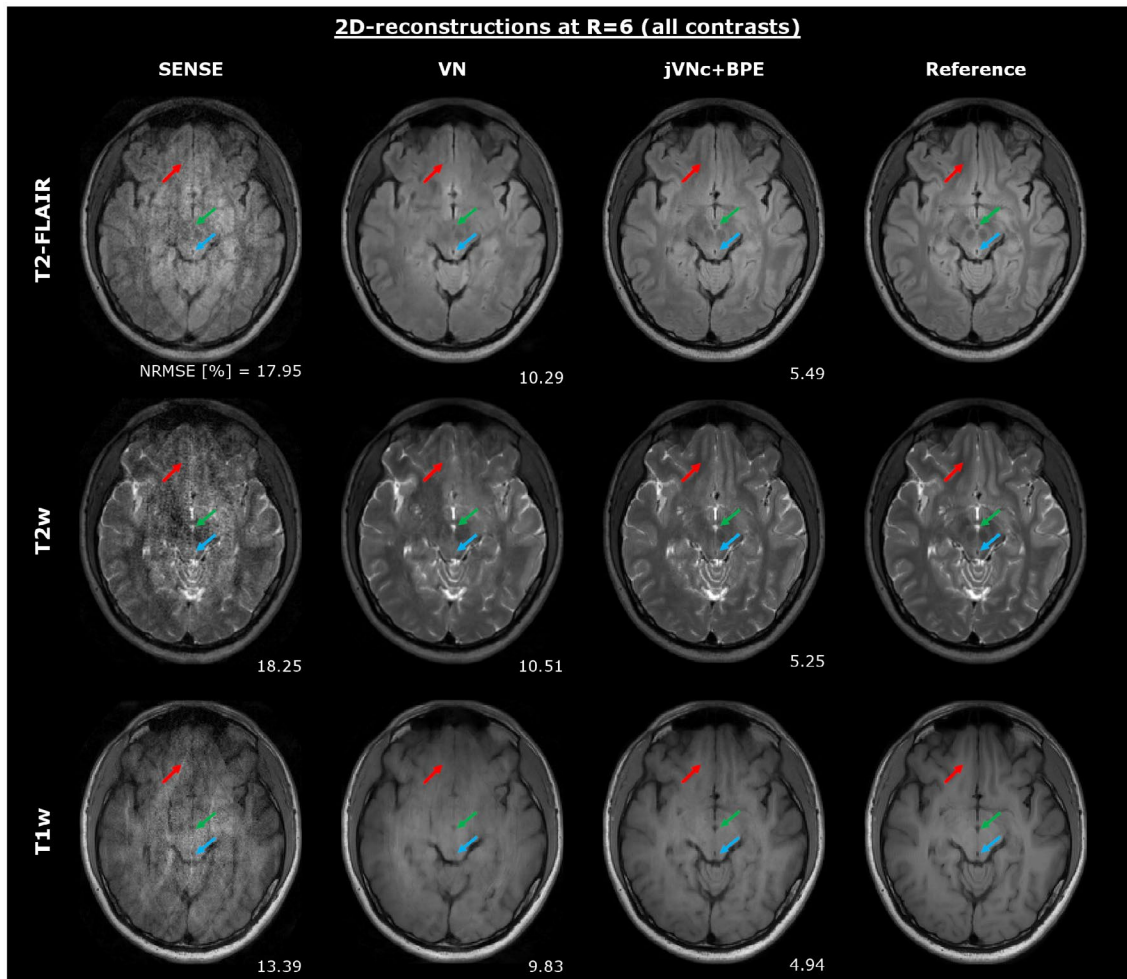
Throughout all contrasts, *jVNc + BPE* better preserved the spatial resolution (red arrows) and achieved lower NRMSE compared to *VN*. Moreover, the comparison demonstrates that *jVNc + BPE* retained the scan-specific contrast. Signal leakage from one contrast to another was not observed, as exemplarily demonstrated for a region of CSF (green arrows) which is hyper-intense in T2w, but dark in T1w and T2-FLAIR. Moreover, *jVN* distinguished the structure of CSF from the structure of a blood vessel (blue arrows) even though the shape and size were similar (low-signal intensity of blood was retained for all contrasts)
